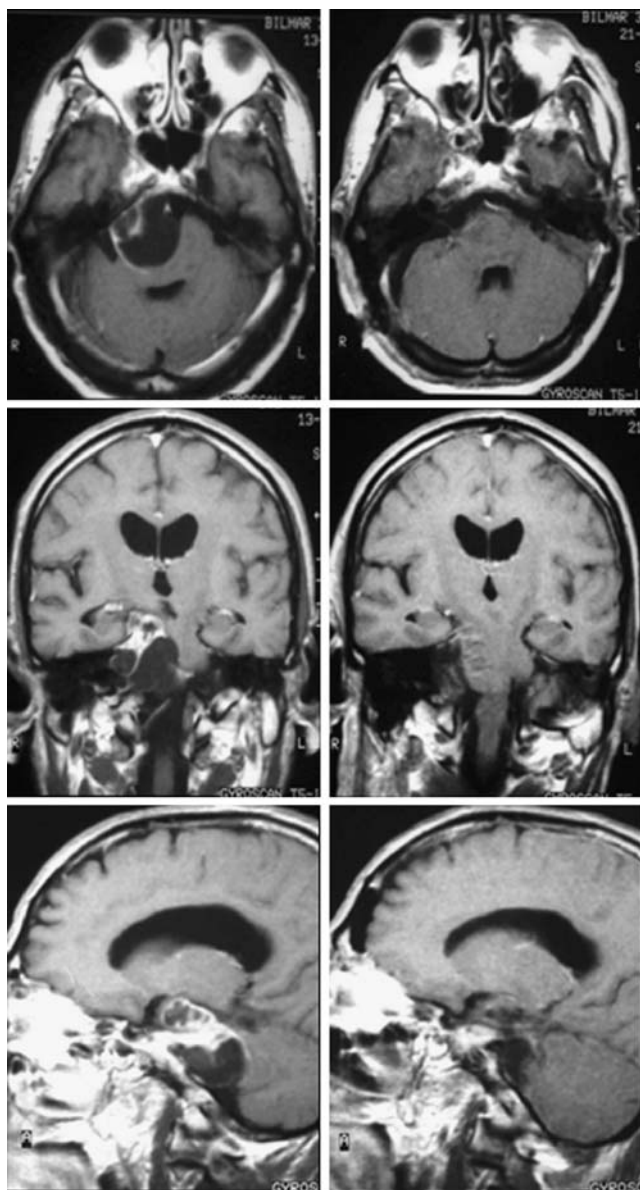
Preoperative (left column) and postoperative (right column) MR images show a type B trigeminal schwannoma. Note the cystic degeneration and displacement of the pons caused by tumor compression
